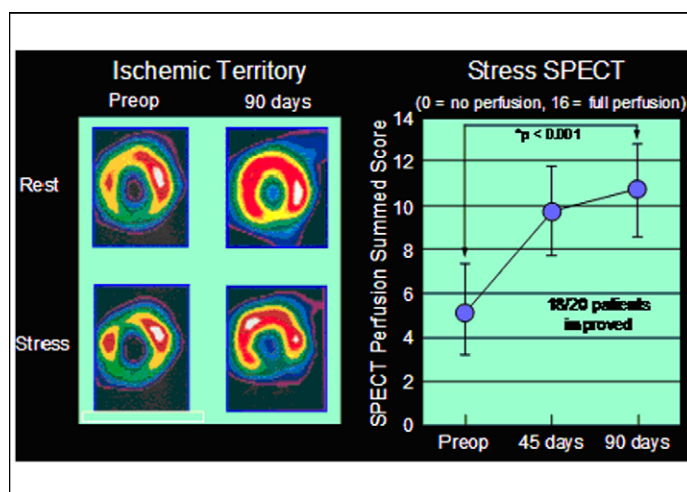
Improvement in blood perfusion in the heart as demonstrated by SPECT analysis following FGF-1 administration. ^{99m}Tc-sestamibi stress SPECT imaging of the left ventricle preoperatively and 90 days after FGF-1 treatment as sole therapy for no option heart patients [10]. Significant post-treatment improvement of myocardial perfusion was seen in this trial. SPECT: single photon emission computed tomography.
